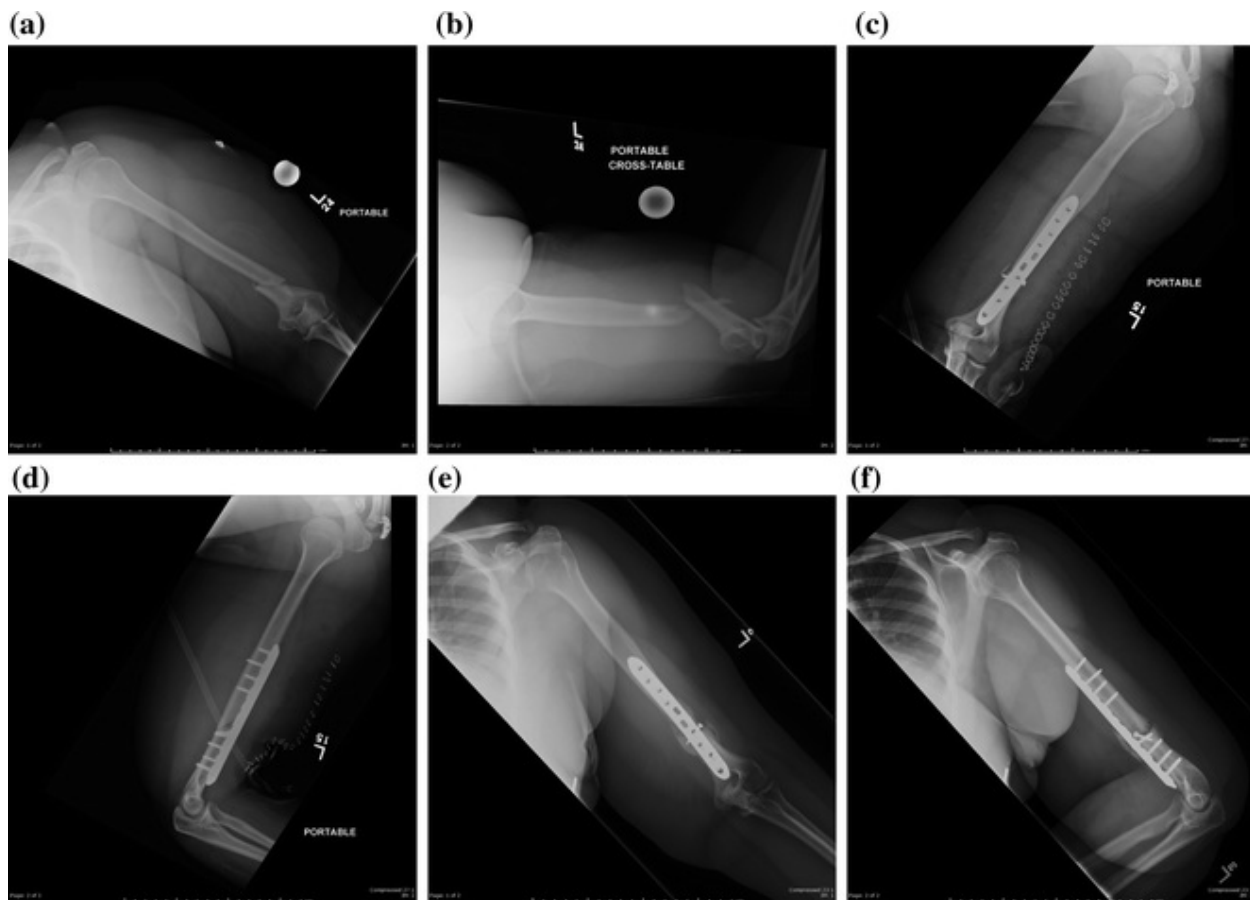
a, b. Injury radiographs (anteroposterior [AP] and lateral) of patient with *left* humerus fracture after a motor vehicle collision. c, d Postoperative radiographs (AP and lateral) after open reduction and internal fixation performed in an effort to obtain absolute stability. e, f Follow-up radiographs (AP and lateral) showing unintended callus formation due to micromotion despite attempt
